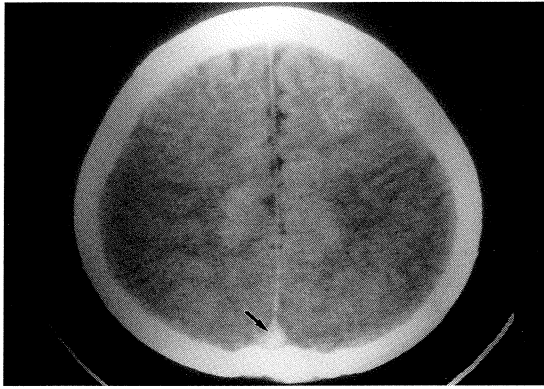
Unenhanced CT scan shows the 'dense triangle sign' due to a clot in the posterior aspect of the superior sagittal sinus (arrow).
